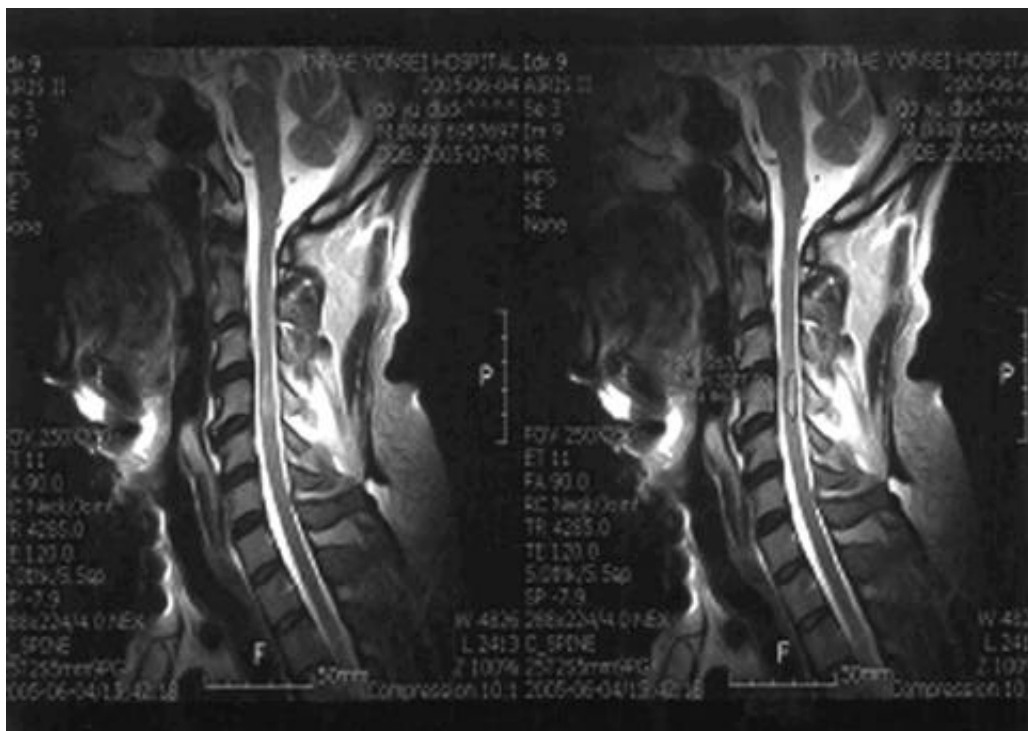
Quantitative analysis of signal changes on MRI(PACS system). (SD: standard deviation, mean, area : mm²)
